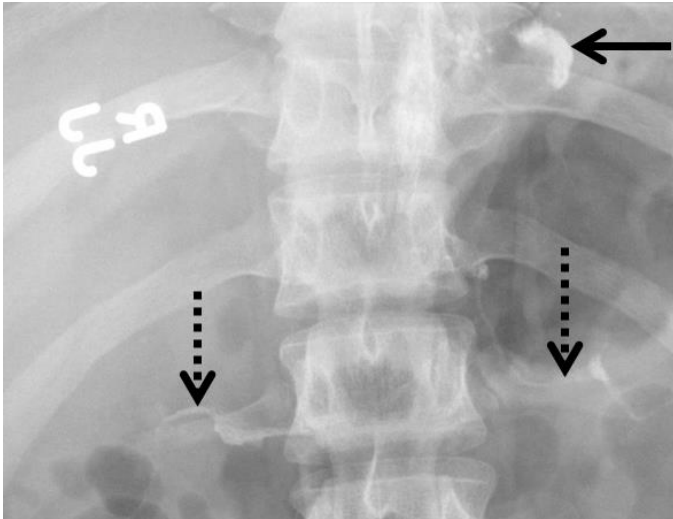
A 22-year-old man who presented with intermittent hematuria was found to have visceral artery embolization of injected Enteryx. A plain radiograph of the abdomen showed a cashew nut-shaped radiopaque density at the gastroesophageal junction (solid arrow), suggesting the site of injection of Enteryx. The dotted arrows indicate linear densities in the expected regions of the renal arteries.
